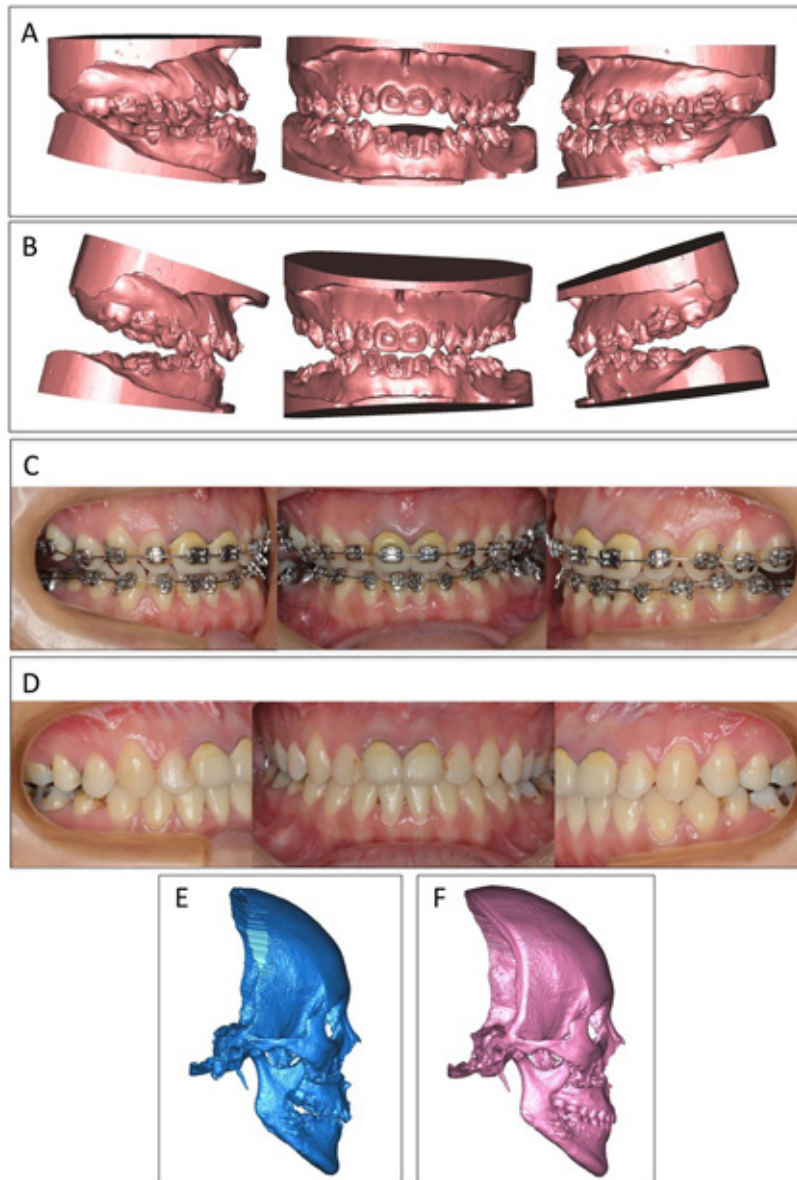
Occlusion setup and postoperative occlusion correction in an extreme case undergoing the SFA. A Preoperative dental occlusion indicated a Class III anterior open bite with an accentuated maxillary compensating curve; B the occlusion was set up as a positive anterior overbite, Class I premolar relation, and large posterior open bite; C the 0.014 NiTi leveling wire was inserted 1 day before OGS, light intermaxillary elastics were inserted after OGS, and the anterior occlusion was gradually settled at 6 weeks after surgery; D completion of the treatment at 11 months after OGS; E CBCT obtained 1 week after surgery; F CBCT obtained after completion of the surgical orthodontic treatment.
